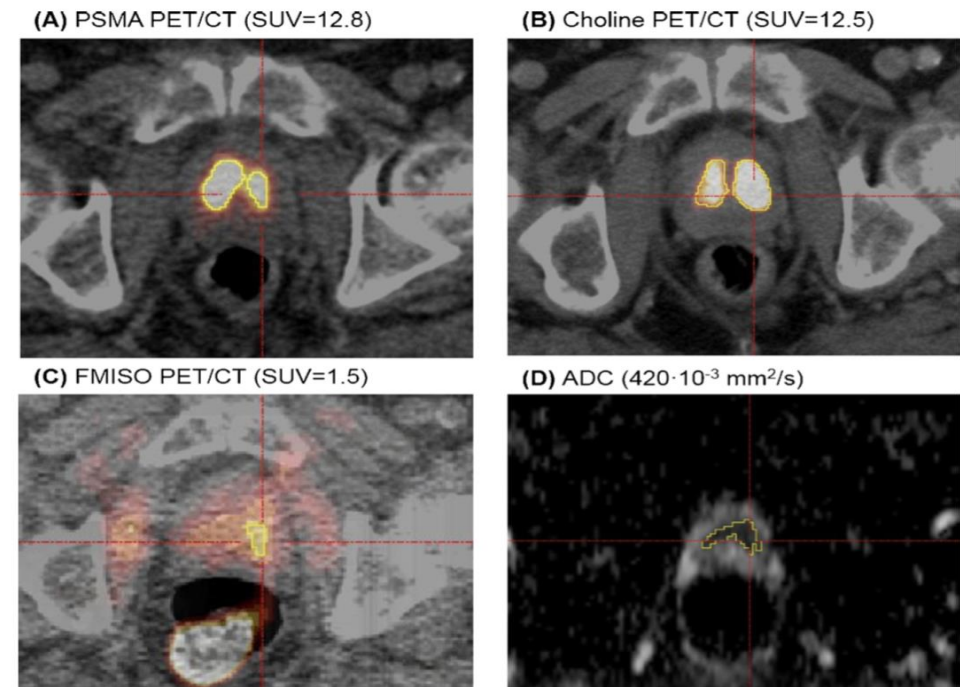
Screenshots of the same anatomical position of PET/CTs with tracer accumulation in the prostate for PSMA (A), Choline (B) and FMISO (C) and the ADC map derived from DW-MRI (D). Additionally, in each image the PET- or ADC-positive contour is shown. Those contours were defined automatically using a threshold of 50% SUV_{max} for PSMA and Choline PET/CT, $\text{TMR} = 1.4$ for FMISO PET/CT and 30% ADC_{min} for DW-MRI.
